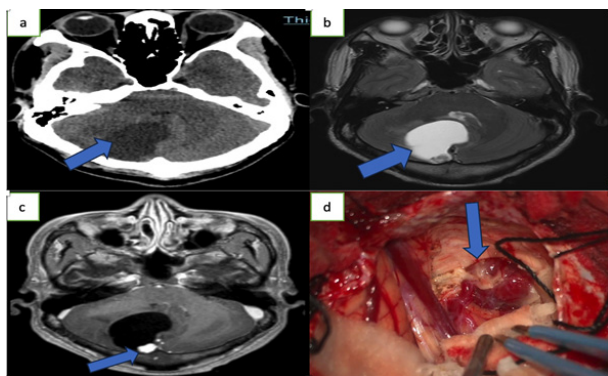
Plain CT head axial section (a) showing cystic lesion (arrow) in right cerebellar hemisphere effacing the 4th ventricle. T2-weighted axial section (b) showing well-defined cystic intra-axial mass lesion in the right cerebellar hemisphere along with eccentric mural nodule showing avid enhancement of nodule (c). Intra operative image (d) showing variegated red and yellow colored mass lesion.
